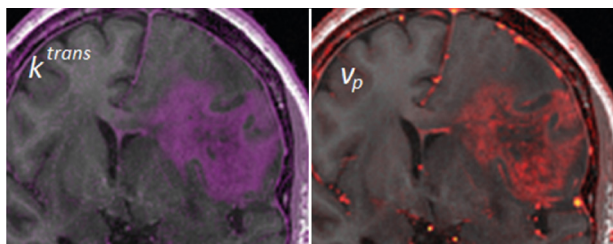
K^{trans} and v_p maps on T1-weighted image, showing vessel leakage (left) and microvascular changes (right) expected from tumor growth. Patient was imaged 4 months post-surgery.
